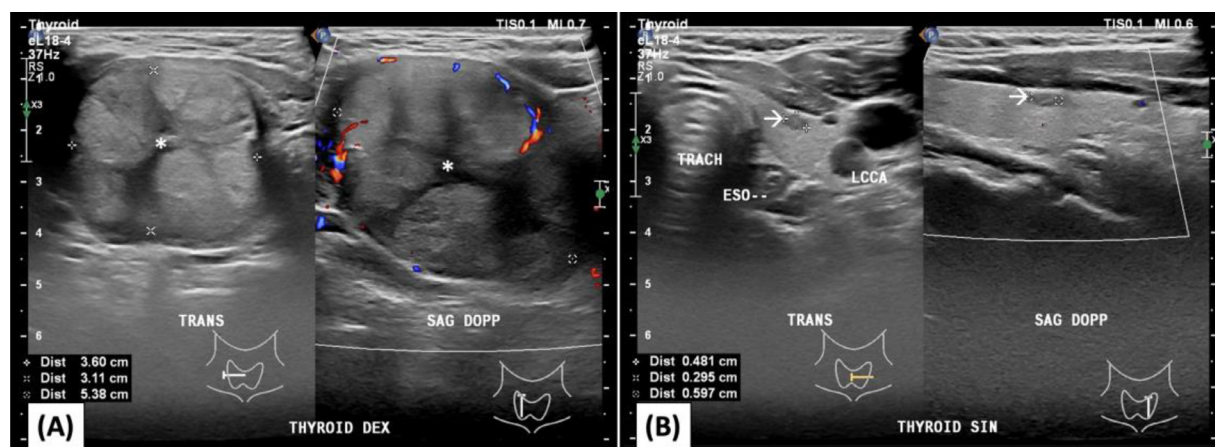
Thyroid ultrasound showed a mass classified as TIRADS-4 in the right thyroid lobe (asterisk) and a small lesion classified as TIRADS-2 in the left thyroid lobe (arrow).
